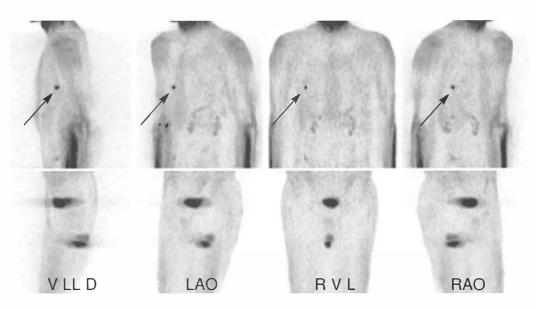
MIPs in same views as in figure 1 of a patient (69/f) after surgical treatment of a malignant melanoma located at the right leg. Note multiple metastases in <sup>18</sup>F-FDG-PET (arrows). However, a total of six metastases located within the skin area could not be identified by <sup>18</sup>F-FDG-PET imaging but by an accurate clinical examination.
